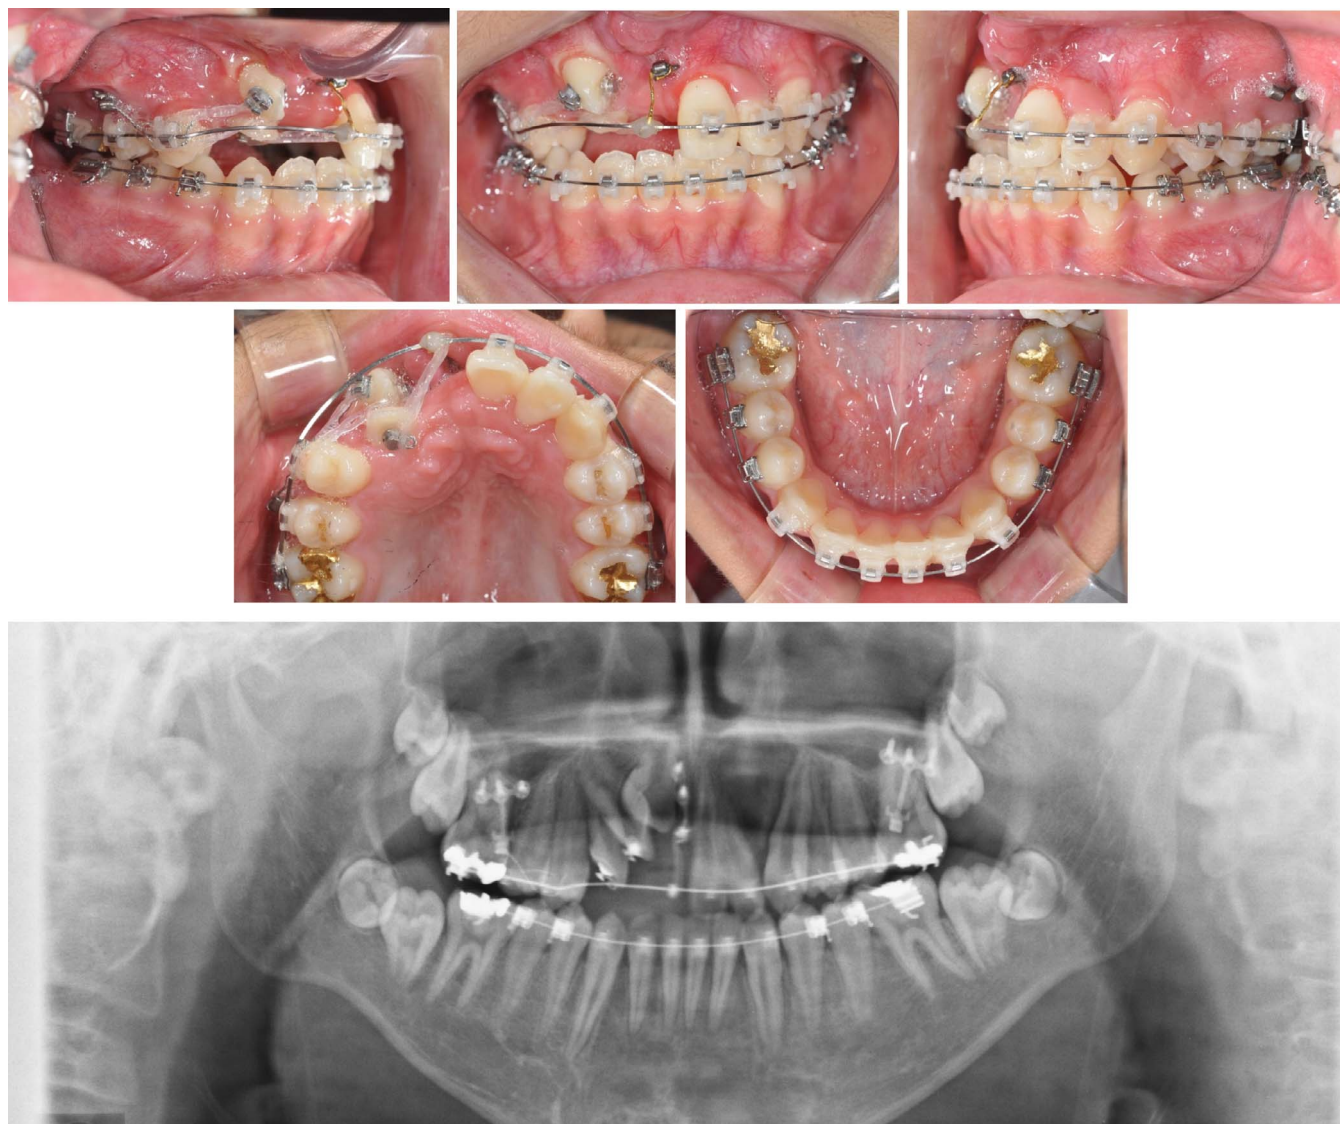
Intraoral photos and panoramic radiograph at 7 months after starting traction of teeth 12 and 13.
